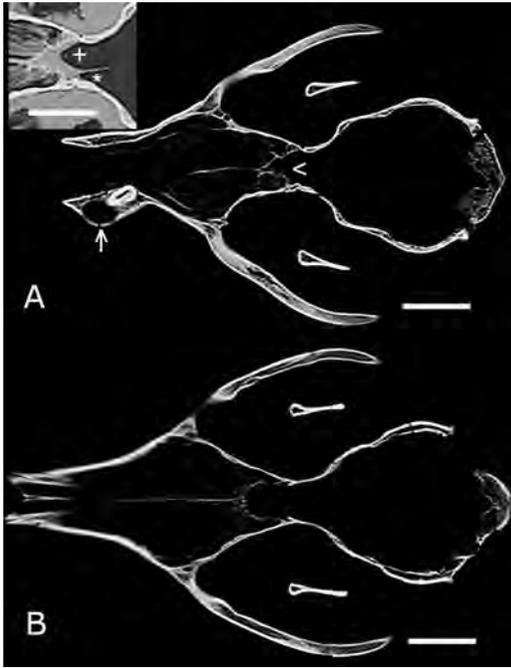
Computed tomography (CT) dorsal view of macerated gray wolf (*Canis lupus*) skull with deformities compared to a control. Bars=3 cm. (A) Note odontogenic cyst (arrow); deformity and sclerosis of cribriform plates (white arrowhead); and increased osseous density of maxillary, frontal, and zygomatic bones. Inset is CT dorsal view of fleshed (brain removed), affected gray wolf head. Reduced space of rostral neurocranium with variance from left (asterisk) to right (plus sign) side. (B) CT dorsal view of macerated, control gray wolf skull.
